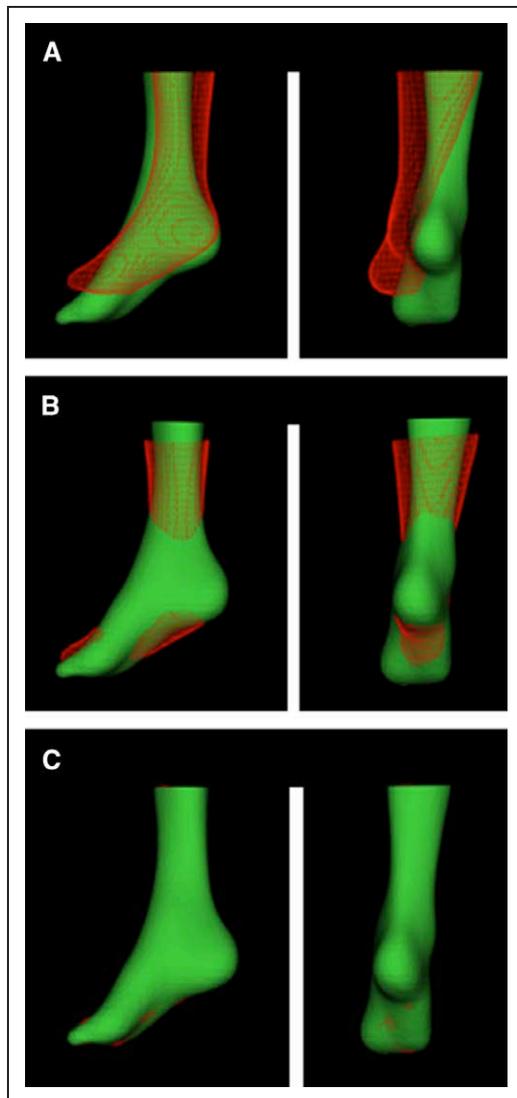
Serial registration of x-ray computed tomography foot images for assessing test-retest reliability of single photon emission computed tomography/CT perfusion imaging.
